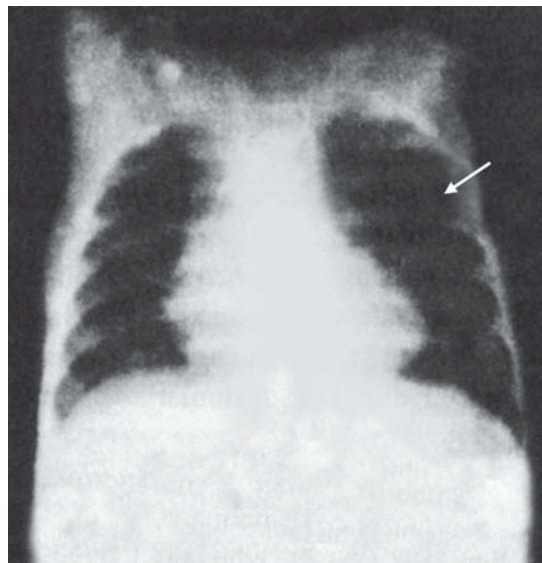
Chest X-ray in tetralogy of Fallot. Note the boot-shaped heart and oligemic lung fields.
